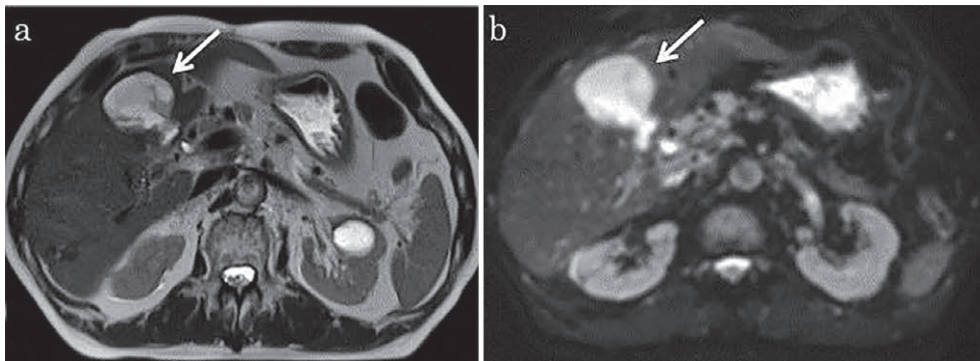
Abdominal magnetic resonance imaging after 7 weeks of treatment. T2-weighted image (a) and diffusion image (b). Arrows show the segment 5 operation site with acute cholangitis that improved well with antibiotics.
